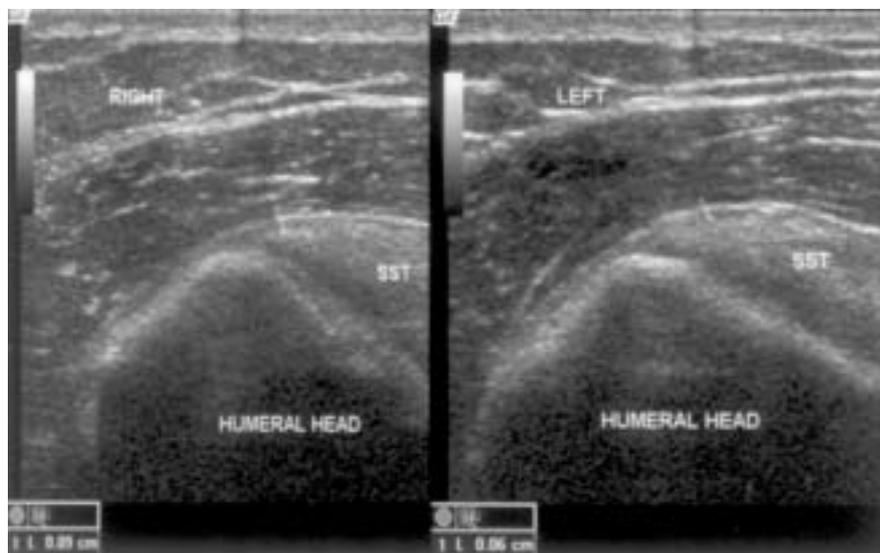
The 47-year-old female patient had right shoulder pain with limited motion for 4 months. Ultrasonography showed thickening of subacromial bursa and peribursal fat. The right supraspinatus revealed no obvious hypoechoogenic changes and was classified as Neer stage I. The bursal thickness was 0.09 cm in right symptomatic side and 0.06 cm in the left asymptomatic side.
